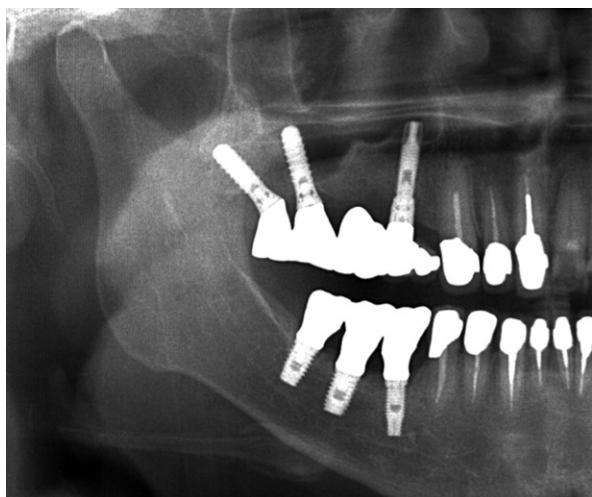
A panoramic radiograph taken at a regular visit for follow-up, 7 years after the placement of the implant. Although it shows that the implant was placed close to the inferior alveolar nerve canal, the patient had no symptoms of paresthesia at that time. No particular radiolucent area was observed around the implant.
